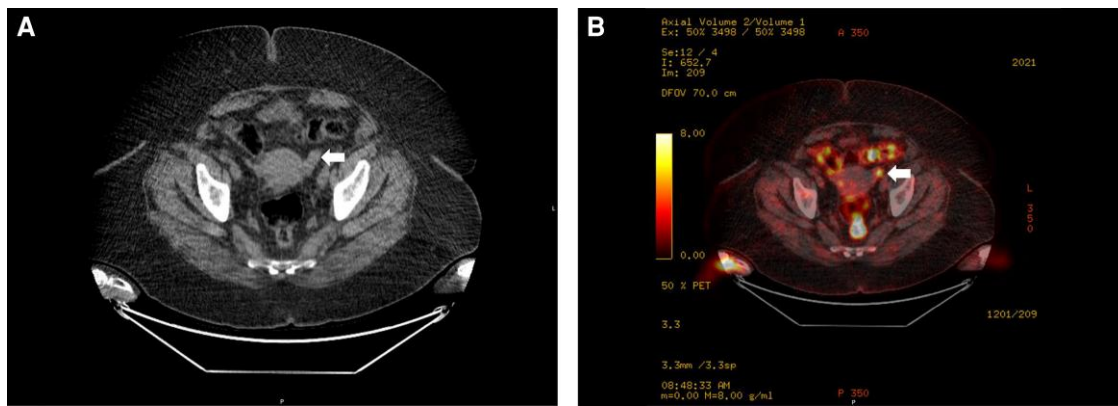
18F-fluorodeoxyglucose PET/CT, skull base to thigh. (A) CT scan showing a left adnexal mass as identified by the white arrow; (B) PET scan showing a left adnexal mass with hypermetabolic activity as identified by the white arrow.
